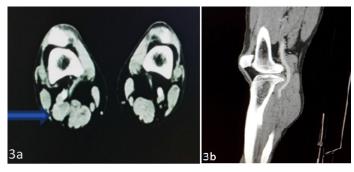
Contrast enhanced indirect CT venography confirming the presence of a saccular aneurysmic venous dilatation in the popliteal vein in sagittal and axial cross-sections.
